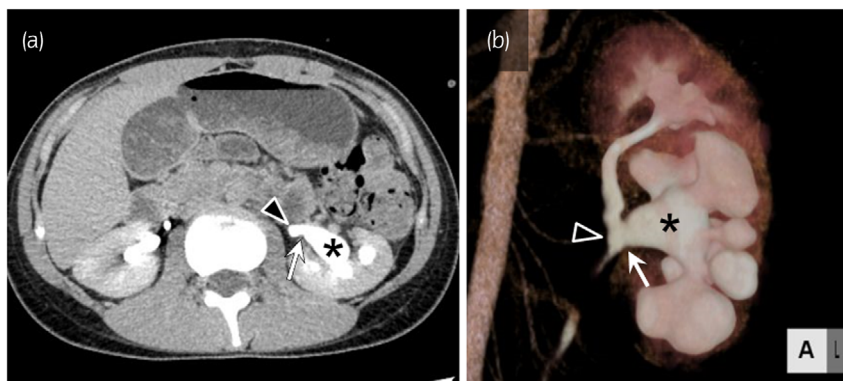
Postoperative CT findings. CT-delayed urography in the transverse plane (a) and three-dimensional CT in the coronal plane (b) revealing no lower moiety UPJO. The arrowhead indicates the common ureter where the upper and lower moiety ureter meet. There is no stricture at the anastomosis (arrow) and no dilatation of the upper moiety ureter. Asterisks indicate the renal pelvis of the lower moiety.
